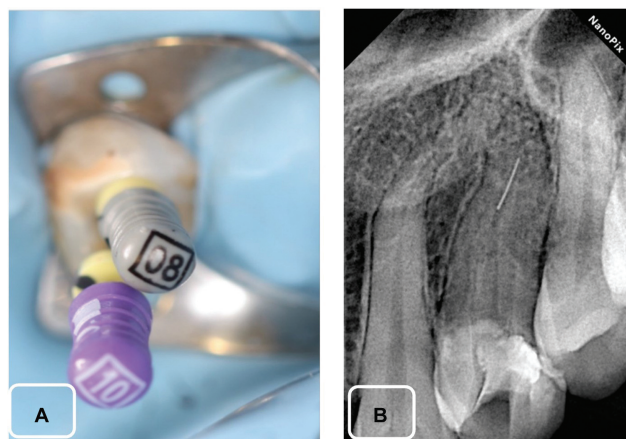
(A) Negotiation of root canals with K files. (B) Radiographic confirmation of separated endodontic instrument.
